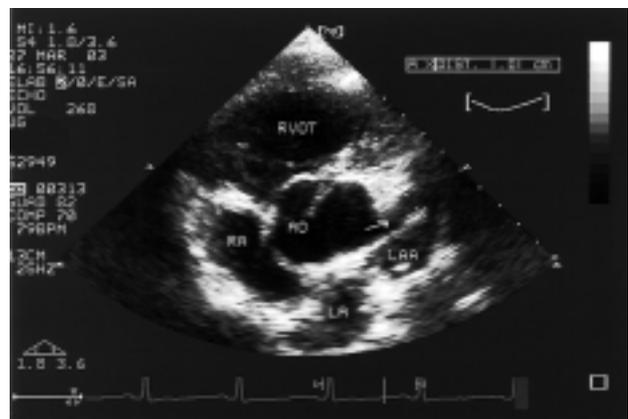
One-year echocardiography showing unchanged dimensions of the residual chamber. The white arrow indicates the residual tract of the fistula originating from the left Valsalva sinus. AO = aortic root; LA = left atrium; LAA = left atrial appendage; RA = right atrium; RVOT = right ventricular outflow tract.
